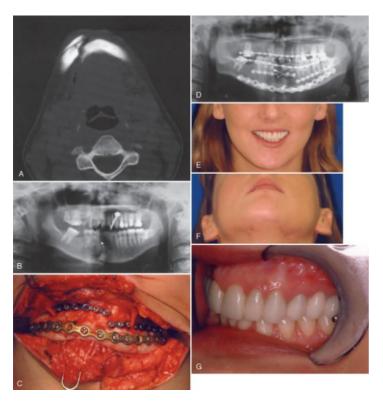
Twenty-four-year-old woman involved in a motor vehicle accident. A, Non-contrast-enhanced axial computed tomography (CT) scan showing comminution of the inferior border of the mandible. B, A panoramic radiograph obtained before the CT scan shows comminution of the right parasymphysis, a left body fracture, and a right condyle fracture with numerous craze lines. C, The patient had a large laceration of the chin and submental region that was extended 2 to 3 cm along the left mandibular radje region. First, monocortical miniplates and a locking screw system were used to piece the borny fragments together. The larger spanning rigid plate was then adapted to the inferior border and locking screws inserted. D, Postoperative panoramic radiograph showing maxillomandibular fixation, which was maintained for 2 weeks to treat the right condyle fracture in closed fashion. E, Three months' postoperative facial appearance. F, Submental view of the healed laceration. The patient declined to have any revision surgery for this. G, Left lateral view of the final occlusion.
